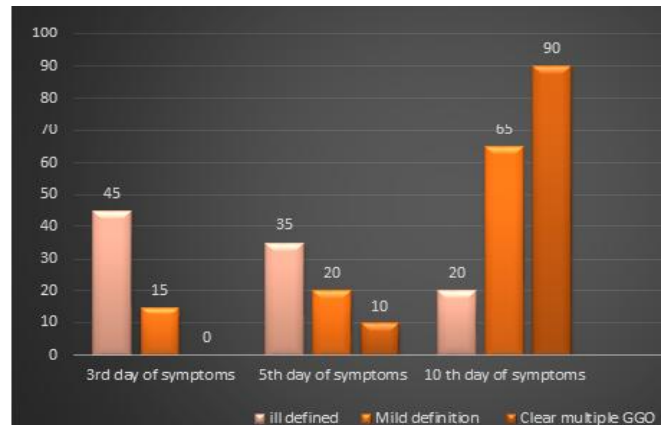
Degree of GGO clarity on HRCT chest on each time series in percentages
